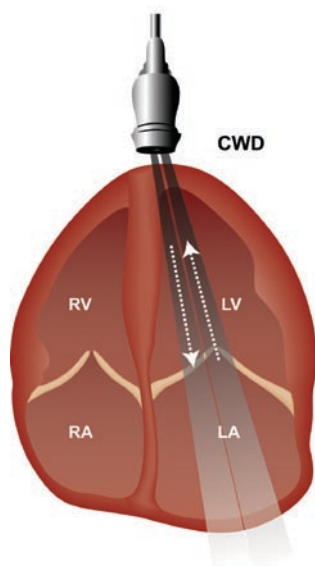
Continuous-wave Doppler imaging utilizes a transducer containing two ultrasound crystals—one that continually emits ultrasound pulses and another that continually receives backscattered waveform
